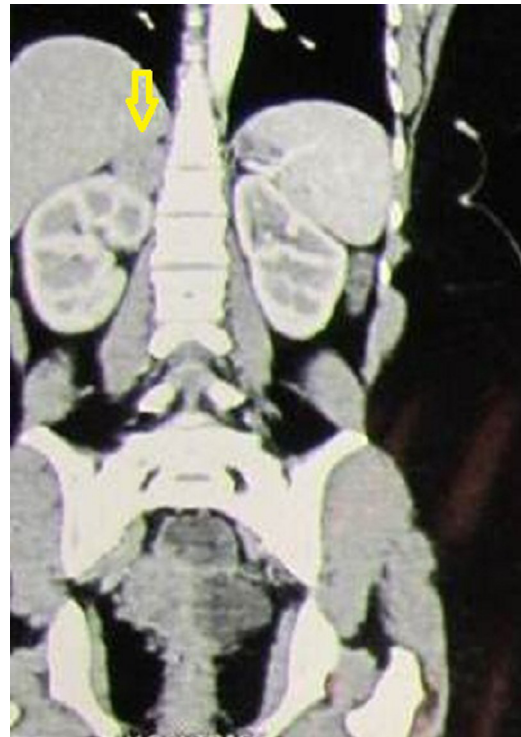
CT image showing small nodule in left adrenal gland.
